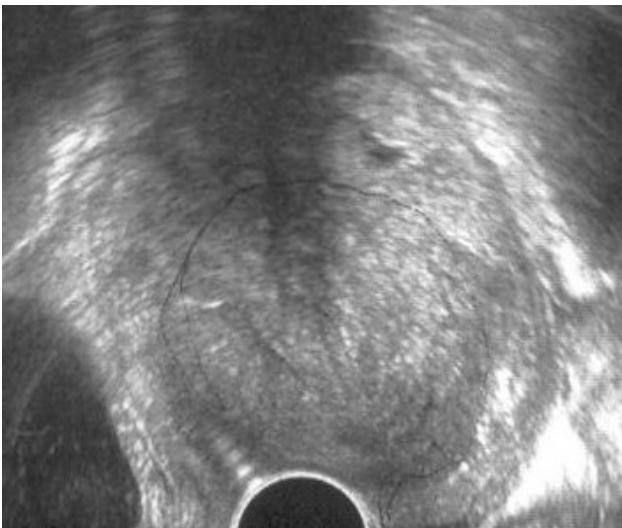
Transvaginal ultrasound performed after vaginal myomectomy. Signs of uterine inversion could be seen.
